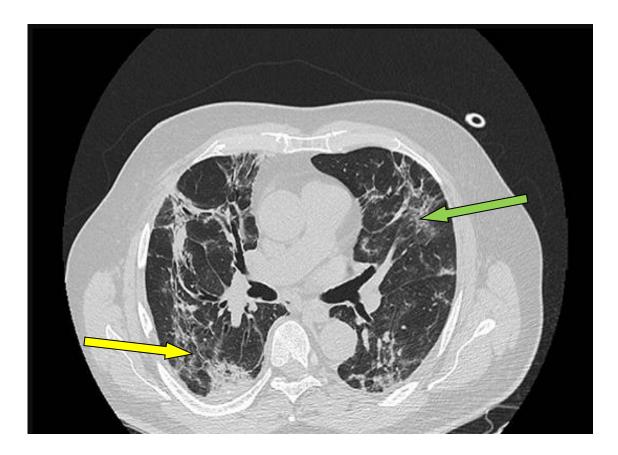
HRCT scan of COVID-19 patient. (radiologyinfo.org) Yellow arrow: pointing towards peripheral vascular marking in lung Green arrow: pointing towards GGO of lung
